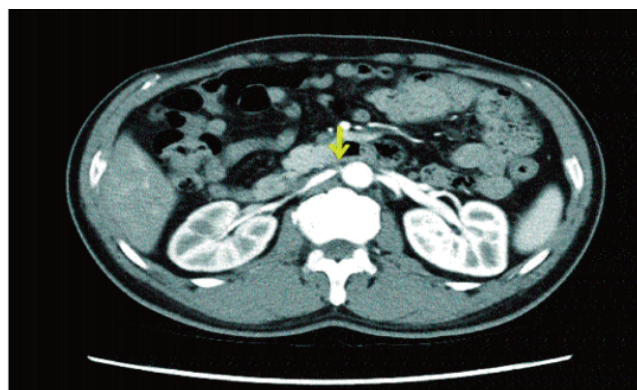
Computed tomography (CT) scan of the abdomen at the time of presentation. Severe atherosclerotic stenosis of the ostium of the right renal artery (Arrow) is observed.
